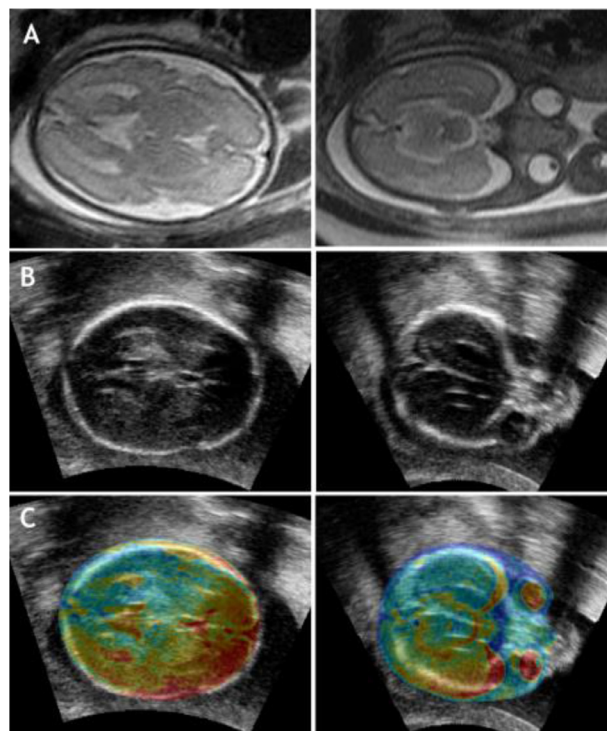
Multimodal image registration of fetal head sequences. (A) MR images; (B) US images; (C) US image with MR information.
